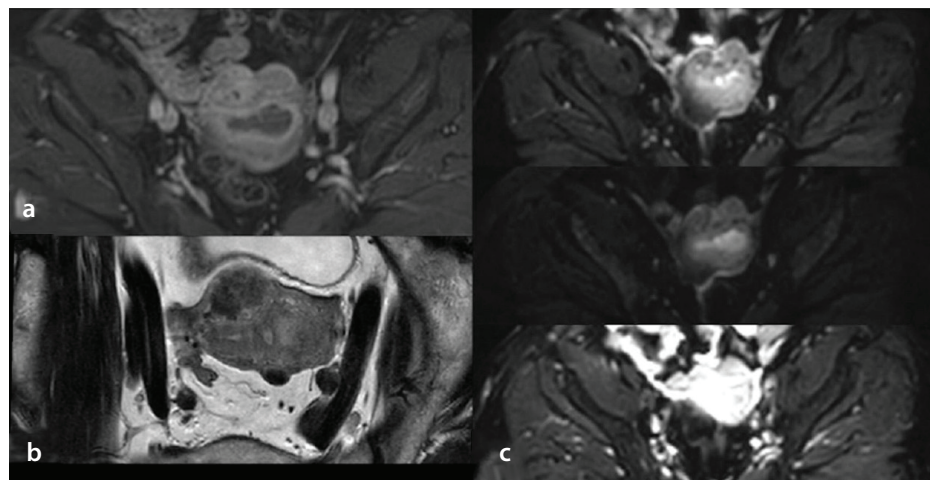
In a 63-year-old patient with a pathological diagnosis of grade 1 endometrial adenocarcinoma of the endometrioid type, the contrast-enhanced series (a) shows a weakly enhancing endometrial mass relative to the myometrium in the arterial phase and heterogeneous subserosal myomas at the uterine fundus. On T2-weighted oblique axial series (b), a mildly hyperintense mass lesion is observed; on DWI (c), a high signal intensity mass is seen. Based on MRI evaluation, the lesion was concluded to have DMI; however, the pathological evaluation showed SMI. DMI, deep myometrial invasion; DWI, diffusion-weighted imaging; MRI, magnetic resonance imaging; SMI, superficial myometrial invasion.
